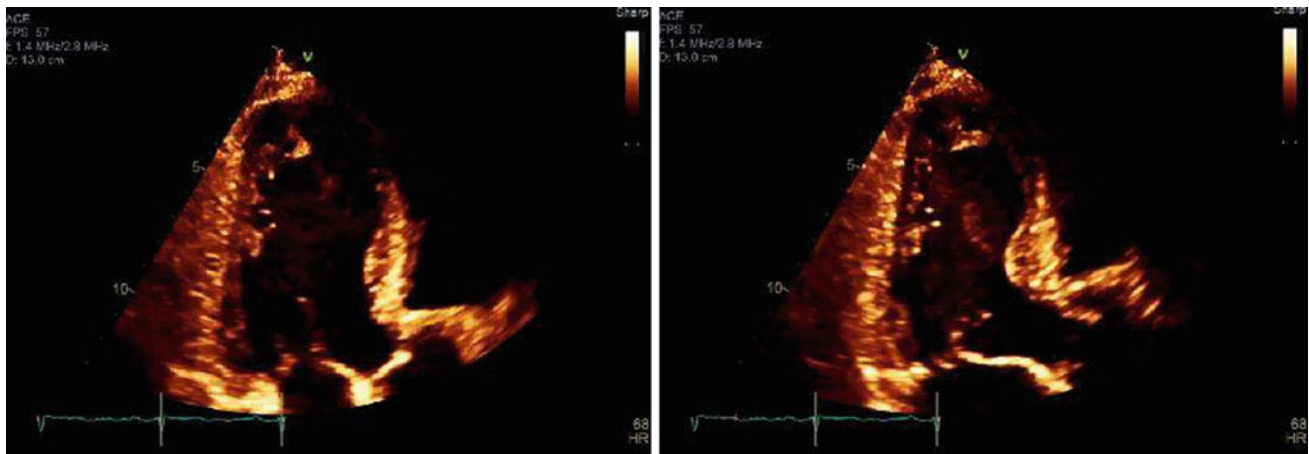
Echocardiographic diastolic (left) and systolic (right) frames showing regional wall motion abnormalities in the lateral wall and apex
